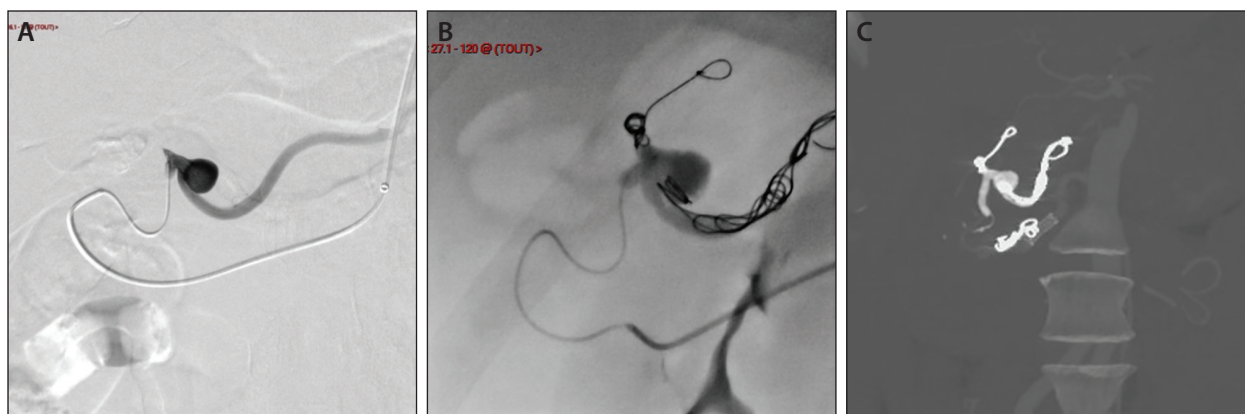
Example of a complex 10-mm aneurysm of the PD artery. The upper aneurysm was treated with detachable coils completed by the liquid embolic Easyx (not FDA approved) (A) and the inferior one with a small stent graft and detachable coils (B). Control cone-beam CT showing exclusion and reduced CT artifact (C).
